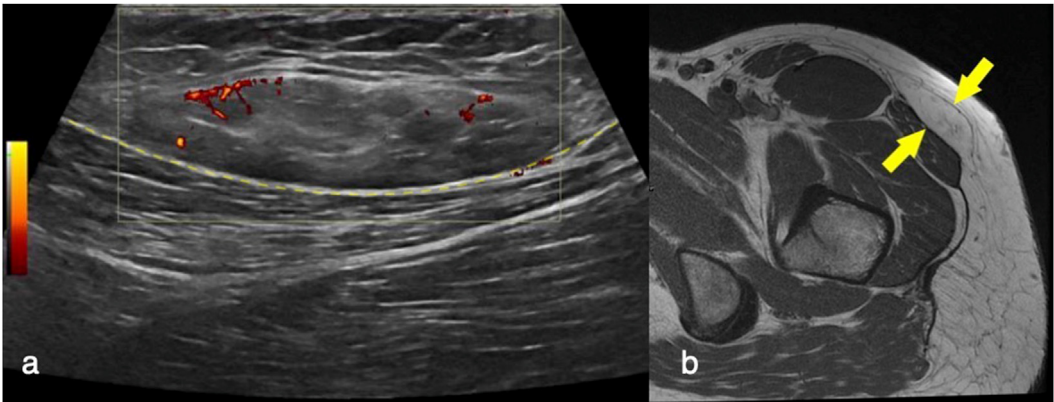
Superficial lipoma. A longitudinal ultrasound view of the left upper thigh (a) revealed a fat-containing lesion in the subcutaneous tissues, which lies superficial to the deep fascia (broken yellow line). Further characterisation with T1W images (b) confirmed a superficial lipoma.
